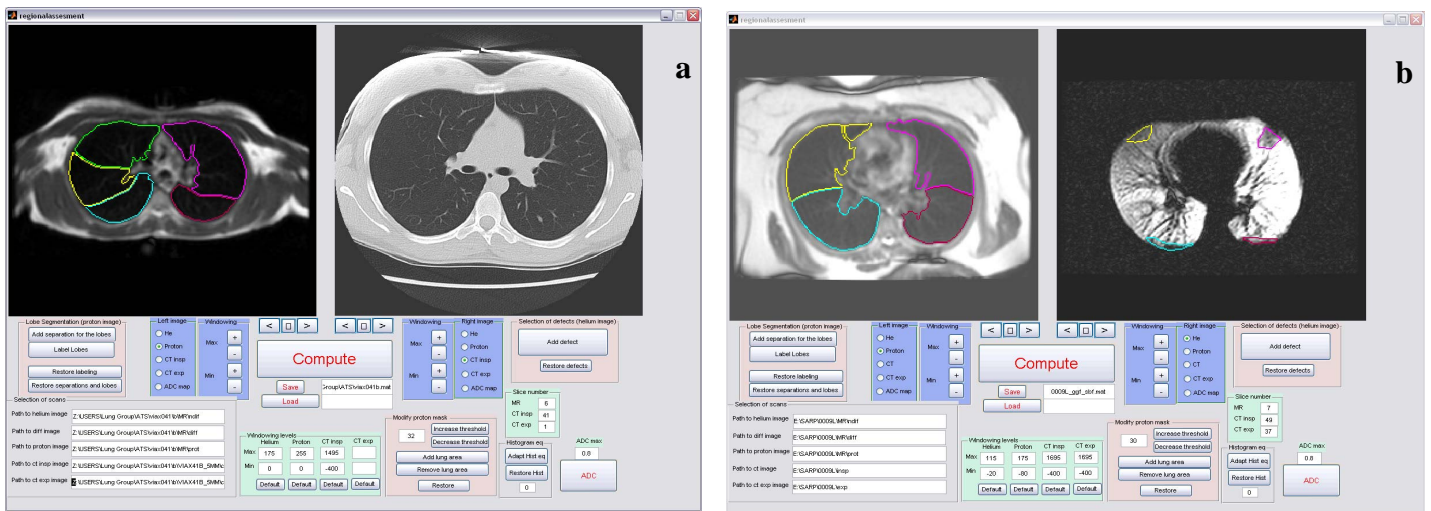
a) An example of the interface, showing a proton MRI scan juxtaposed on the left with the expiratory CT image on the right. b) A different patient with the proton image on the left in registration with the HP He-3 image on the right. In the helium image, it can be seen that the defects are colored based on the lobe in which they reside.
